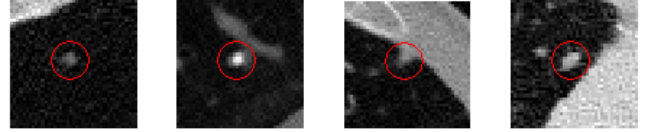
Transaxial CT images with the four types of nodules, shown from left to right, well-circumscribed, vascularized, juxta-pleural and pleural-tail.
